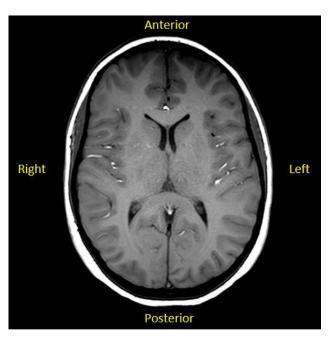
MRI of the head. This is a T1 MRI showing excellent differentiation of the soft tissue of the brain (compare to the head CT in Figure 2).
